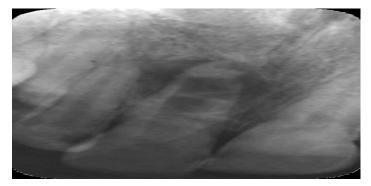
preoperative radiograph showing a wide canal and formation of apical radiopaque hard tissue. Note the presence of periapical and latero-radicular radiographic image.
